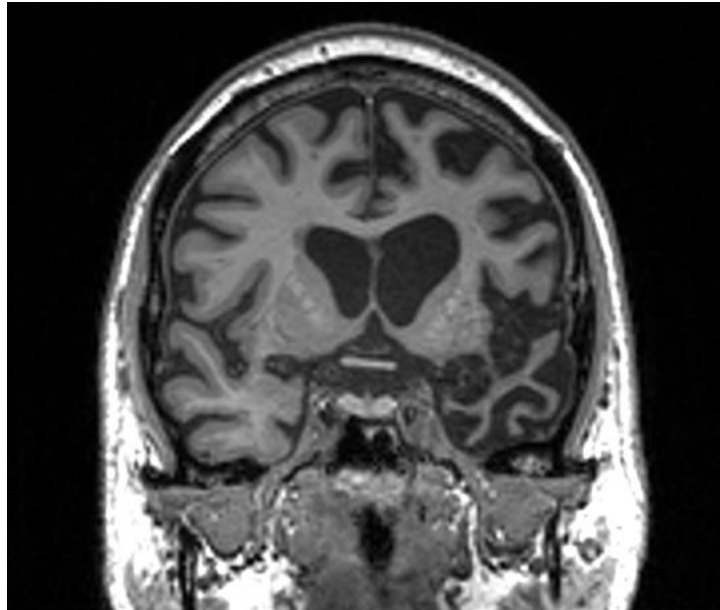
Coronal volumetric T1-weighted MRI of a patient with svPPA. The scan shows characteristic knife-blade atrophy of the left anterior lobe. The left hemisphere is on the right side.
